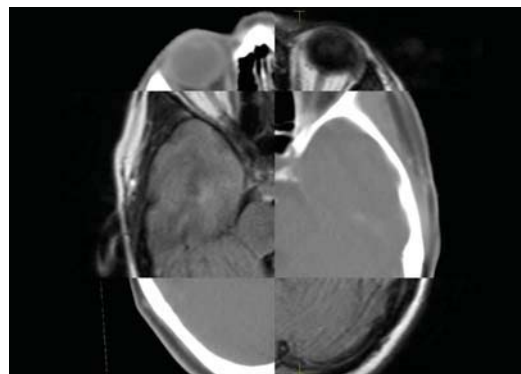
Computed tomography–magnetic resonance imaging (CT-MRI) fusion
